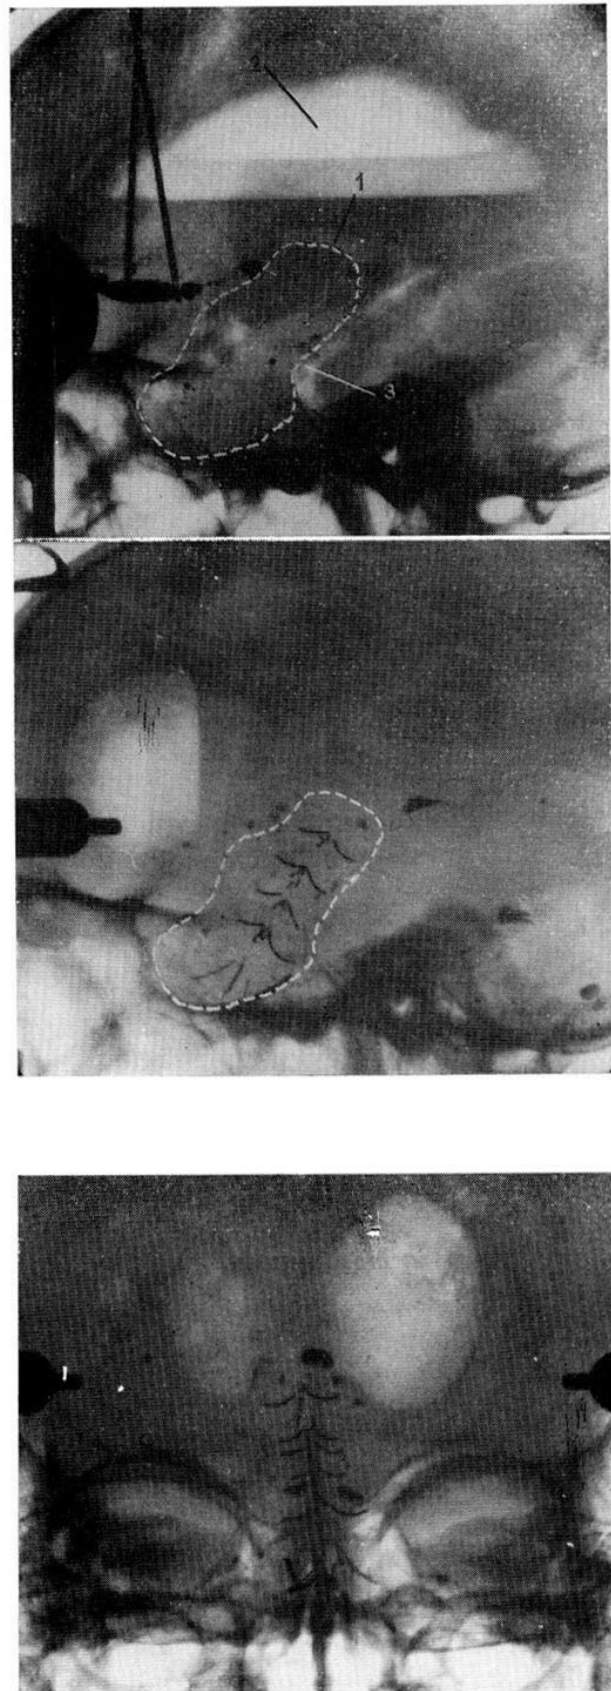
a - b — Lateral and anteroposterior X-ray pictures of iridium 192 implantation in extrasellar chromophobe adenoma (4,6 Mc).
